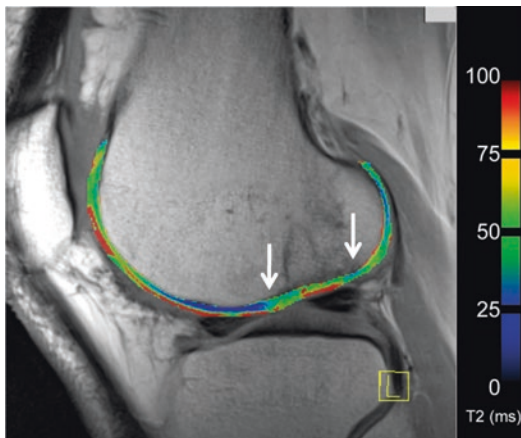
Sagittal multi-echo spin-echo MR image with a color-coded T2 map overlay of the lateral femoral condyle of a 32-year-old male, 6 months after matrix-associated chondrocyte transplantation. Higher T2 values within the repair tissue (arrows) can be appreciated, when compared to the surrounding native articular cartilage. (Acquisition parameters: TR: 1650 ms; TE: 12.9, 25.8, 38.7, 51.6, 65.5, 77.4; flip angle 180°; matrix size: 384 × 384; FOV: 16 cm; slice thickness: 3 mm; slices: 6; TA: 5:37 min)
